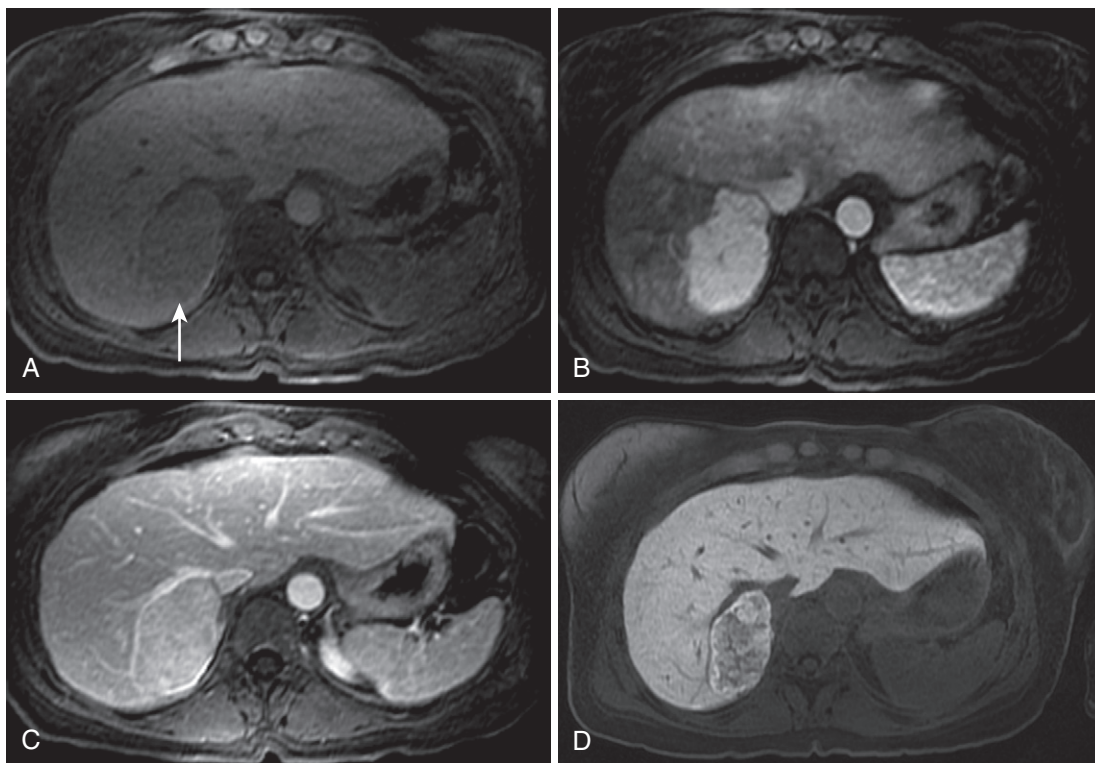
FNH imaging with hepatocyte-specific agent. A, The precontrast image from the dynamic sequence reveals a subtly hypointense lesion (*arrow*) in the posterior segment abutting the right hepatic vein. Following the administration of Eovist (gadoxetate), avid enhancement is observed during the arterial phase (B), followed by near isointensity during the portal phase (C), characteristic of FNH. D, On the delayed T1-weighted fat-suppressed image obtained 20 minutes later, intralesional hyperintensity confirms the diagnosis of FNH.
